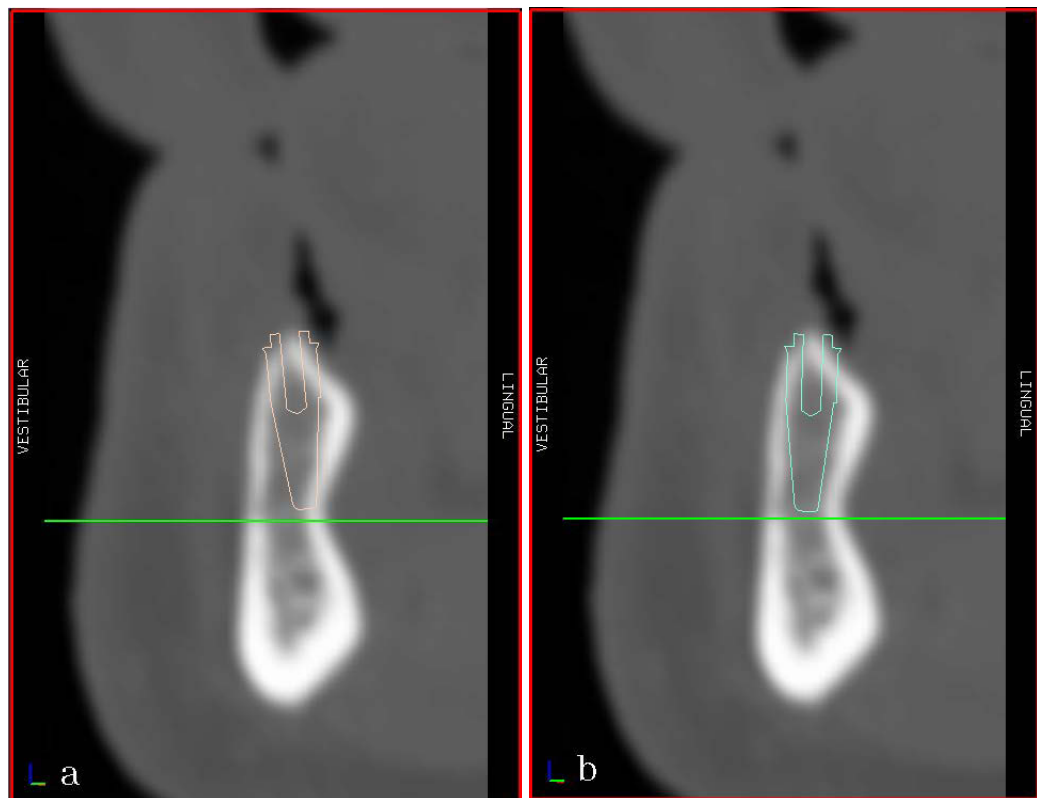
Deep cortical anchorage (a) versus crestal-only cortical preparation (b). The planning software module is used to verify that the implant does not penetrate the lingual wall (a) and has enough cortical support at the implant neck by inspecting the surrounding bone quality via radiographic images.
